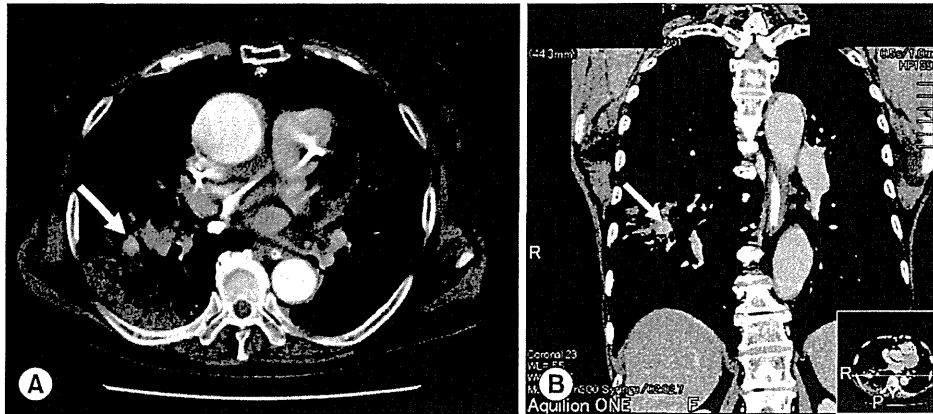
Chest CT just after surgery in the transverse section (A) and coronal section (B). CT revealed a contrast-enhanced false aneurysm measuring 2 cm in diameter in the right PA. Arrow indicates a contrast-enhanced false aneurysm.
